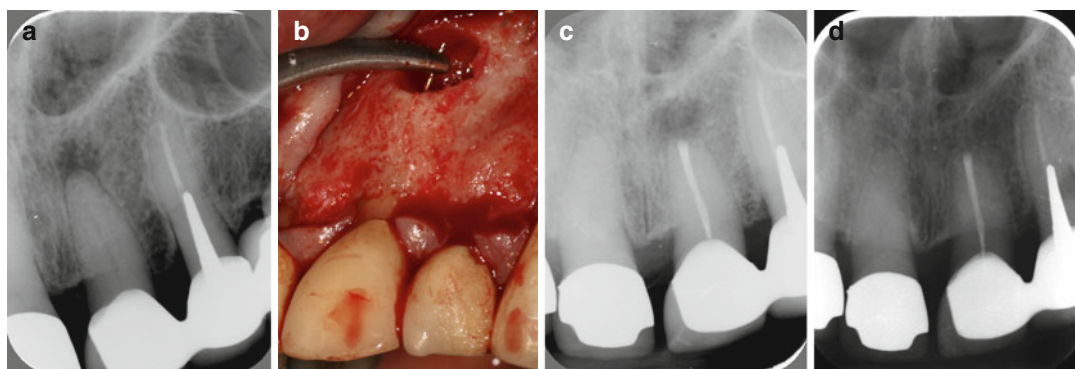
Left central incisor with apical periodontitis and abutment tooth in a bridge. (a) Preoperative radiograph, (b) the root canal was instrumented with hand files in a
